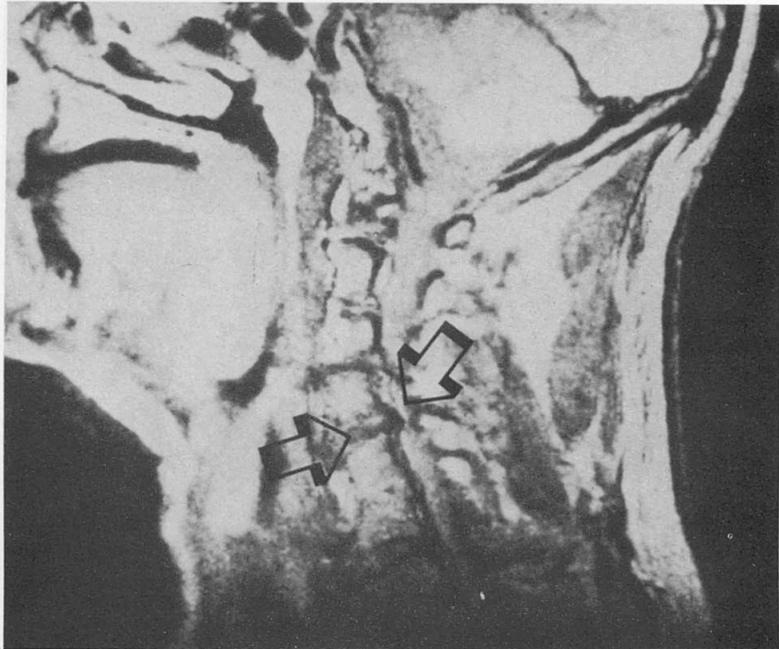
Cervical spine MRI. Arrow at C4-5 intervertebral disc space points in the direction of the spinal cord which measures 6 mm due to compression by a midline disc and calcification (preoperative).
